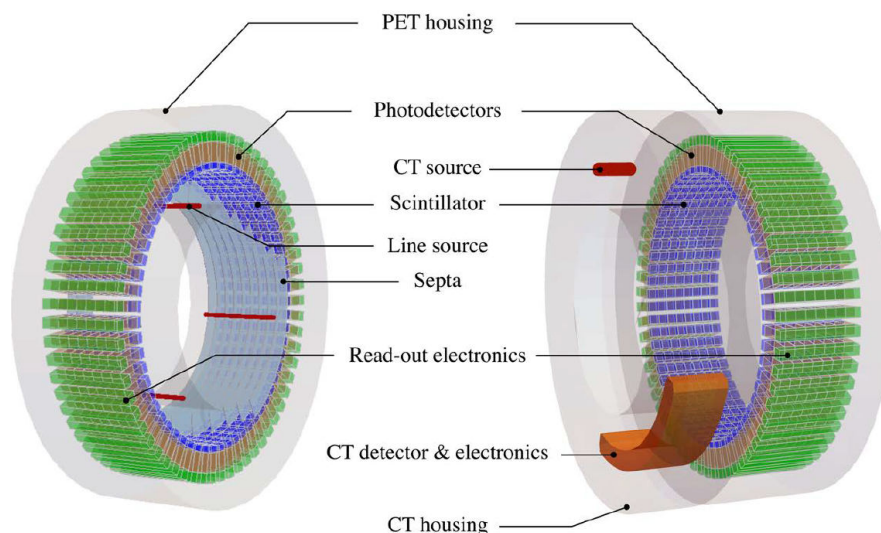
PET system design. Left scheme represents PET scanner. On the right, a combined PET/CT scanner is represented. From *“Hybrid MR-PET Imaging: Systems, Methods and Applications”* by C.W. Lerche, U. Pietrzyk, and M. Lenz. 2019. Page 158. Copyright 2019 by The Royal Society of Chemistry.
